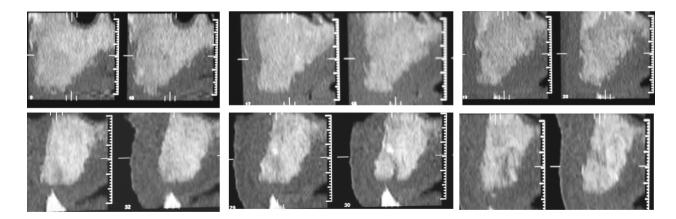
Multi-slice CT of the maxilla before surgery: Para-axial elaborations.
